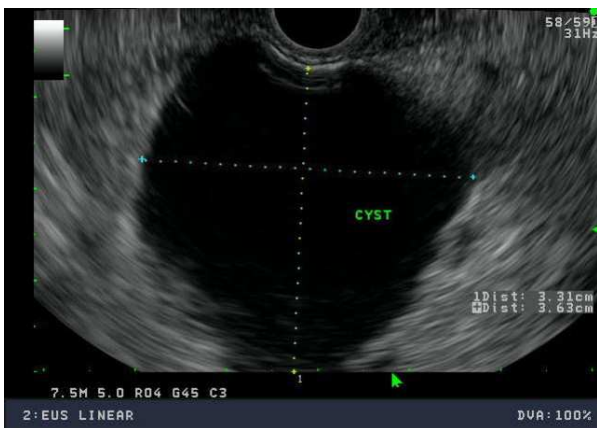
Endoscopic ultrasound image showing the cystic lesion prior to drainage by fine-needle aspiration.
